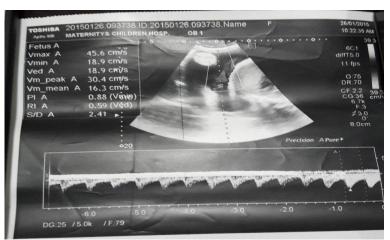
shows normalColor Doppler of the umbilical artery waveform at 23 Wks.
